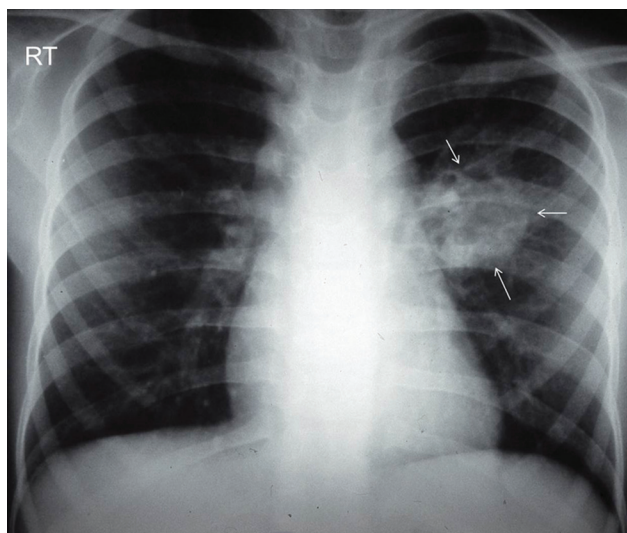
Chest X-ray showing a mass on the left side without hilar lymphadenopathy.
